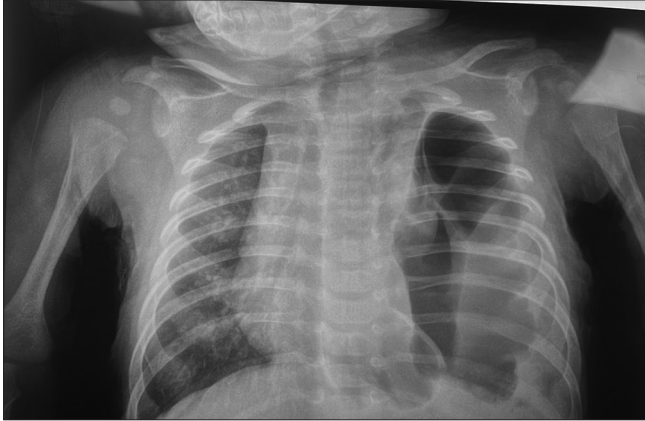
Chest X-ray anteroposterior view revealing findings of congenital diaphragmatic hernia
